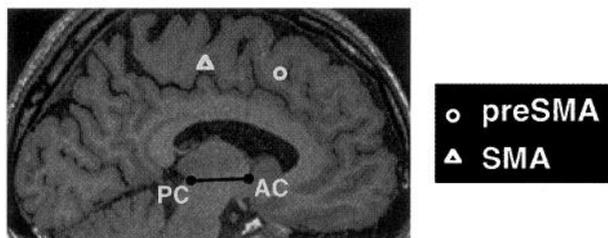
Differential activation of pre-SMA and SMA. In the magnetic resonance image at the top are shown the main locus of learning-related activity ( $\circ$ ) in the pre-SMA and the main locus of movement-related activity in the SMA ( $\Delta$ ) obtained in a single subject. These activities were revealed, respectively, by the learning-vs.-pseudolearning paradigm and the perform-vs.-watch paradigm. In the graphs at bottom are shown, across the consecutive magnetic resonance scans, the cumulative sums of the learning-related activity (left) and the cumulative sums of the movement-related activity (right) for each of the pre-SMA and SMA sites. For comparison are shown the subject's performance (number of completed sets) in these experiments (only for the test tasks). Cumulative % signal change: the percent signal change was essentially the test-minus-control signal intensity at the pre-SMA sites or the SMA site. It was calculated for each test scan by subtracting the average of the signal intensities in the preceding and following control scans from the signal intensity at the given test scan. In this graph are shown the cumulative sum across consecutive scans. Three sessions were performed in series in the learning-vs.-pseudolearning paradigm; 1 session for the perform-vs.-watch paradigm.
